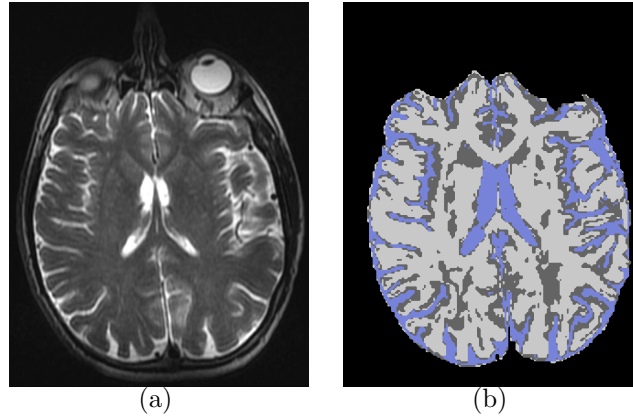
A slice of an MRI-T2w image (a) with the automatic detailed brain segmentation (b), including white matter (white), grey matter (grey) and cerebrospinal fluid (blue).
